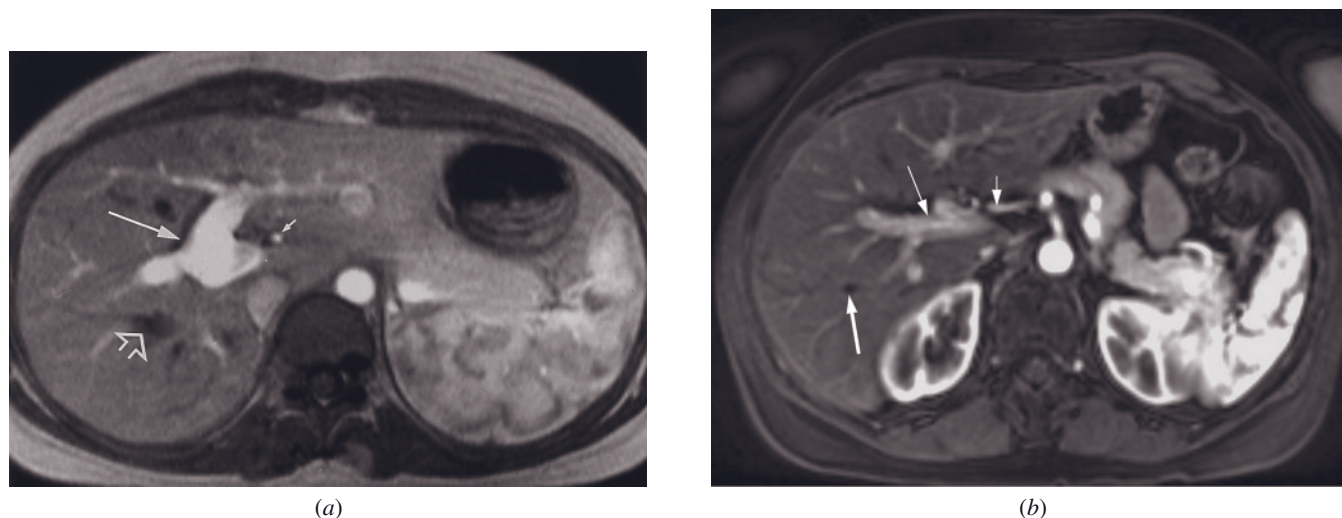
Arciform enhancement in the normal spleen. Postgadolinium T1-weighted SGE image (*a*) acquired at 1.5T on the hepatic arterial dominant phase shows the serpiginous, tubular bands of low signal intensity throughout the splenic parenchyma. Contrast identified in portal vein (long arrow, *a*) and hepatic arteries (short arrow, *a*) and lack of contrast in hepatic veins (open arrow, *a*) define the capillary or hepatic arterial dominant phase of enhancement. Postgadolinium fat-suppressed T1-weighted 3D-GE image (*b*) acquired at 3.0T on the hepatic arterial dominant phase, which is again characterized by the presence of contrast in the hepatic artery (short thin arrow, *b*) and portal vein (long thin arrow, *b*) and by the absence of contrast in the hepatic veins (thick arrow, *b*), demonstrates arciform enhancement pattern of the normal spleen.
